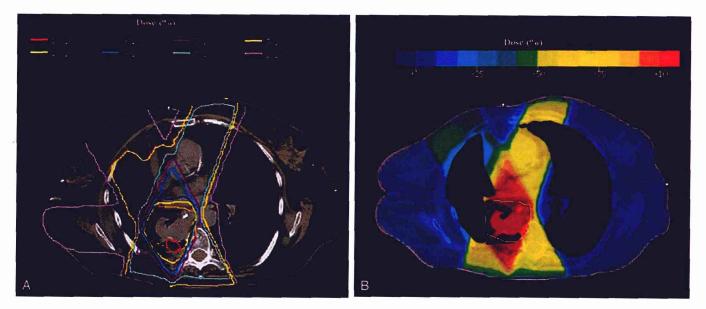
A, Isodose distribution for a lung patient in a transverse computed tomography plane. B, The outline of the planning treatment volume (yellow) is also shown with the same dose distribution as a color wash.
